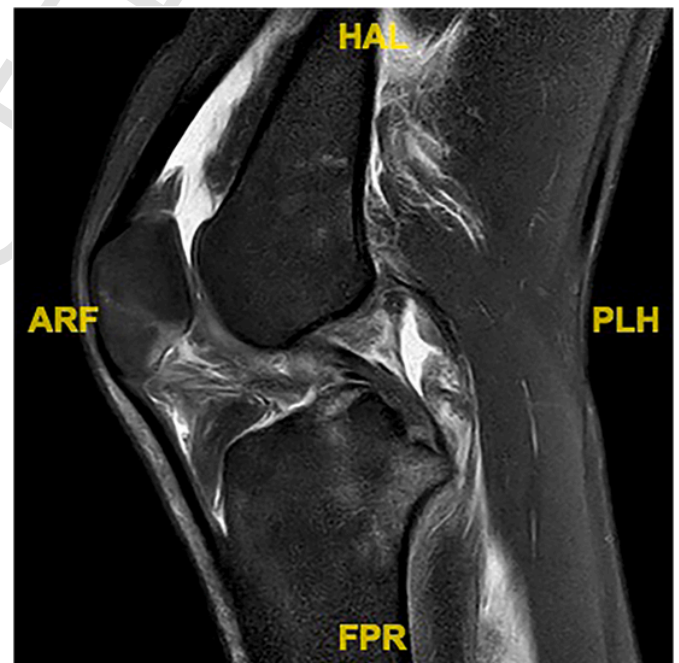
Sagittal T2-MRI confirming an intact PCL.
